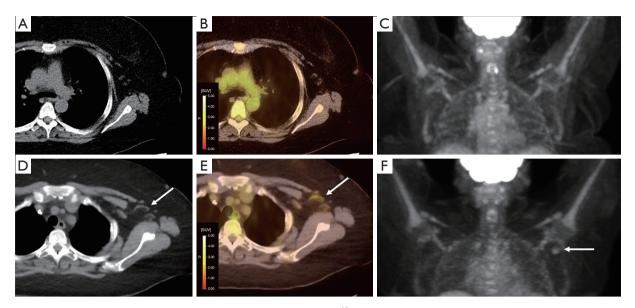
Patient 2: vaccine-related FDG-avid left axillary lymph nodes on ¹⁸FDG PET/CT. Axial CT, fusion and MIP images from baseline (A-C, respectively), and follow-up (D-F) ¹⁸FDG PET/CT studies. Baseline study demonstrates no abnormal or FDG-avid lymph nodes in the left axilla. Follow-up ¹⁸FDG PET/CT 33 days after COVID-19 vaccination demonstrates an increase in size of left axillary lymph nodes with mild FDG activity. The largest lymph node measures 4 mm in short axis on baseline study without FDG activity above background This increased to 12 mm in short axis with an SUVmax of 2.2 (arrows). Given low level FDG activity and proximity to COVID vaccination, findings were presumed to be reactive. These findings were managed conservatively. MIP, maximum intensity projection; SUV, standardized uptake value.
